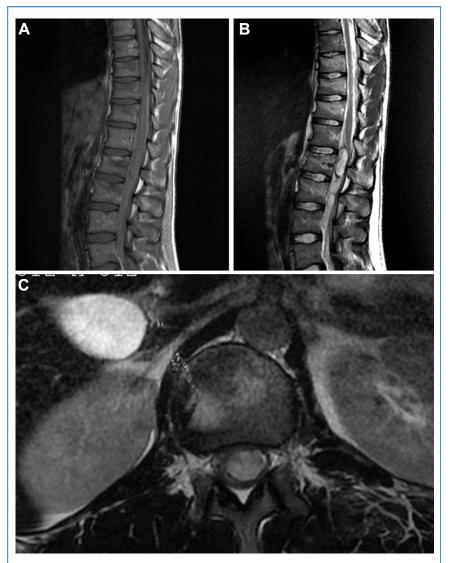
(A) Magnetic resonance image showing spinal cord (cauda equina) compression at the level of L1 and L2 vertebrae by a wide mass that seems to be located in the intradural space rather than the epidural space, appearing isointense in T1-weighted images. (B) Sagittal T2-weighted image showing a hyperintense aspect of the intradural mass. (C) Axial T2-weighted image showing an intradural hematoma widely extended in the spinal canal, pushing the conus medullaris on the right.
